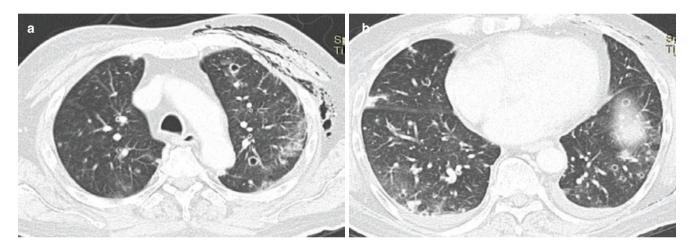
Metastatic angiosarcoma presenting with spontaneous pneumothorax. (a, b) Axial CT images show multiple cystic nodules. Chest wall emphysema is related to chest tube insertion for pneumothorax
